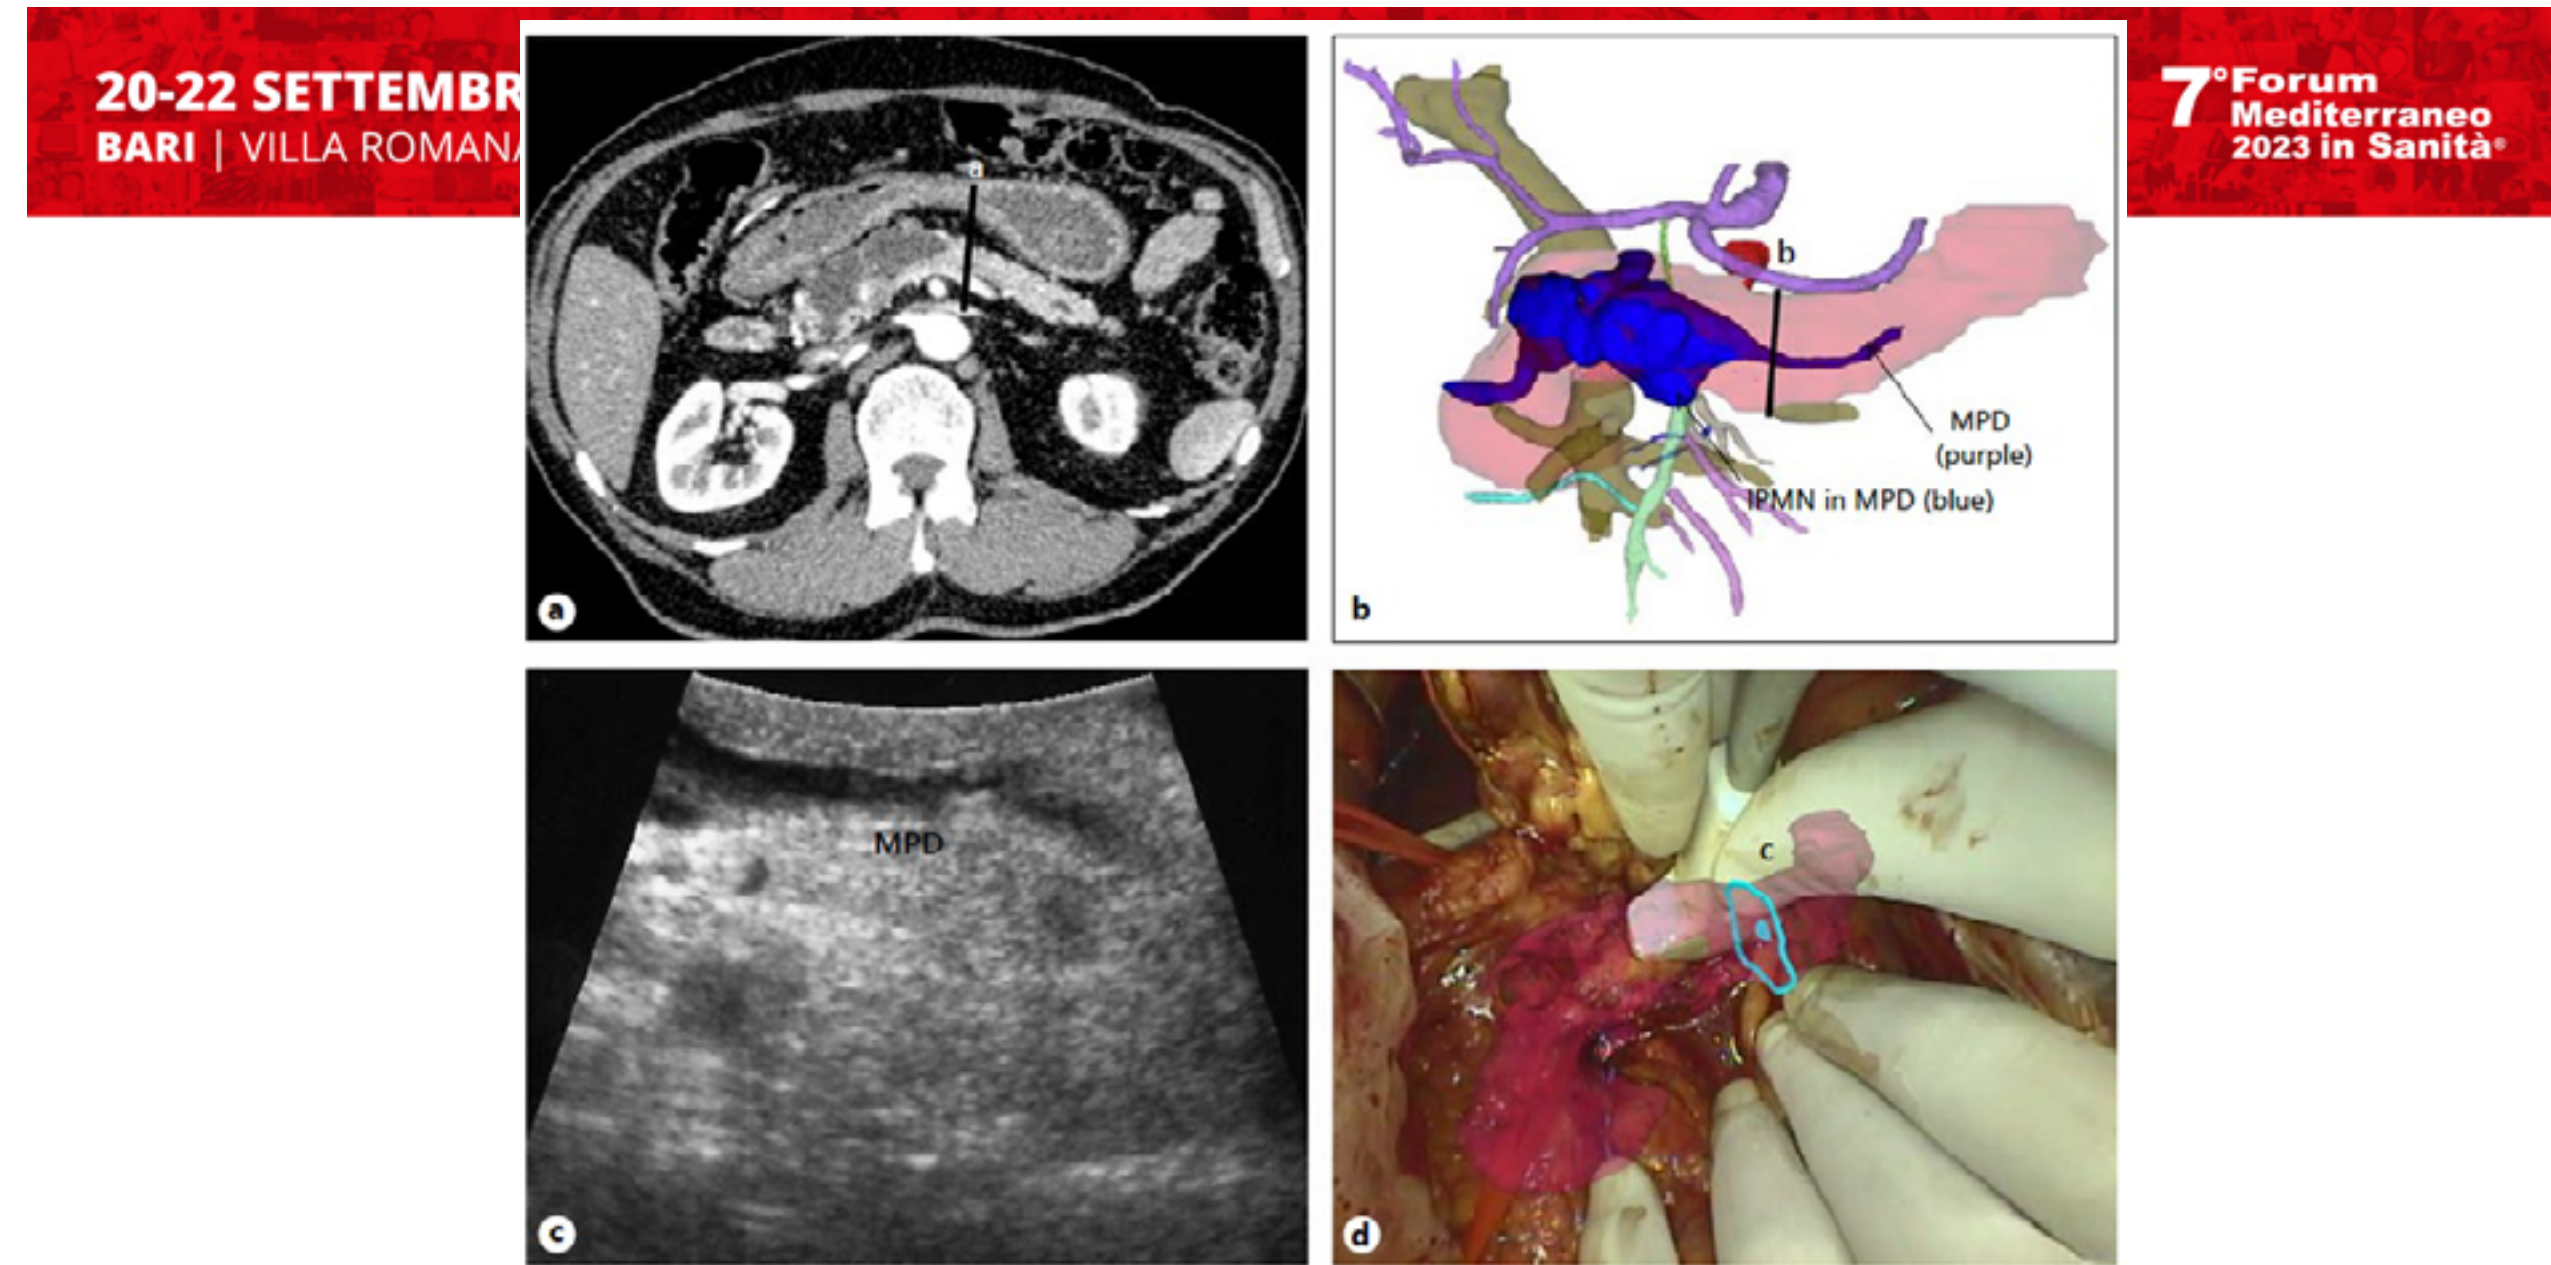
a CT of patient 5 presented the caliber change of MPD and the transection line was determined preoperatively. b The transection line was marked on the reconstructed 3D image. c The transection line was unclear in IOUS. d The overlaid line on the pancreas.
